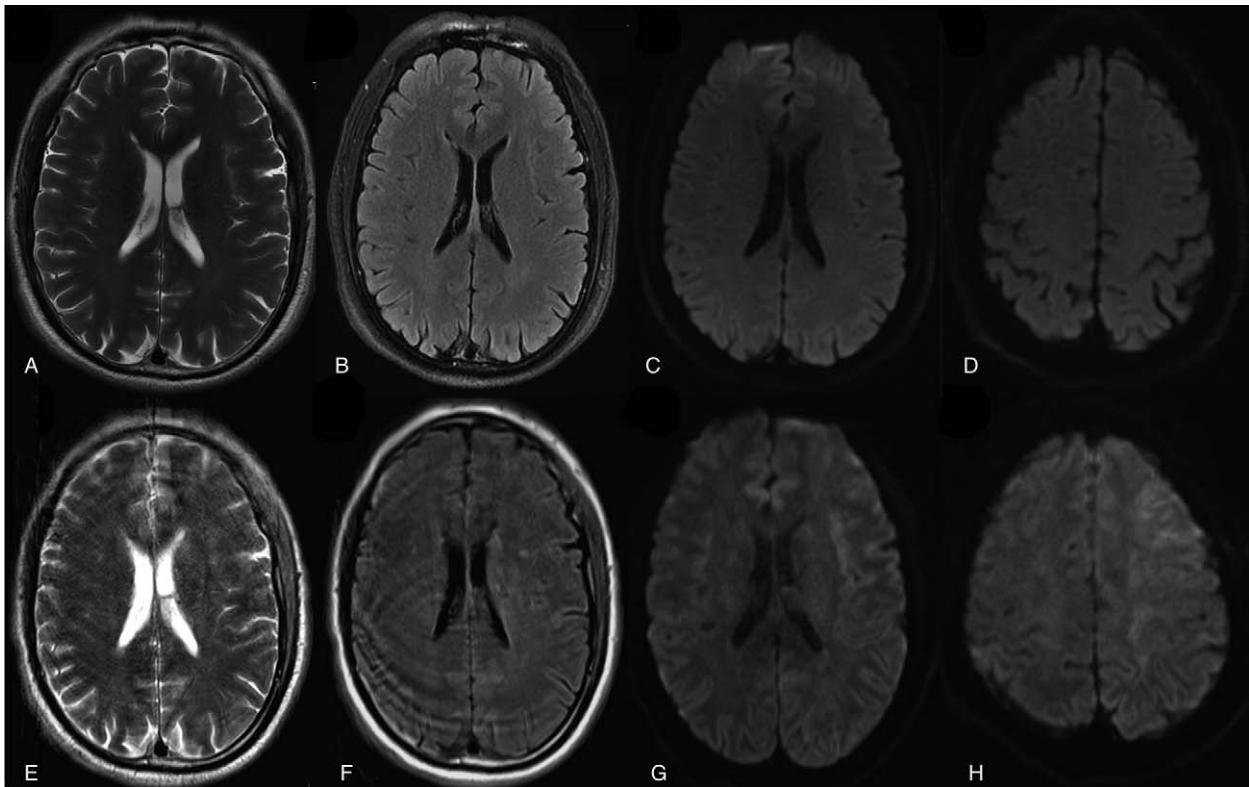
Head magnetic resonance imaging (MRI) before and after operation. (A–D) Inspection of head MRI before the operation showed no obvious abnormality. (E–H) After the operation, MRI showed that fissures, sulci, and gyri have abnormal magnetic memory signals in the regions indicated by arrows.
